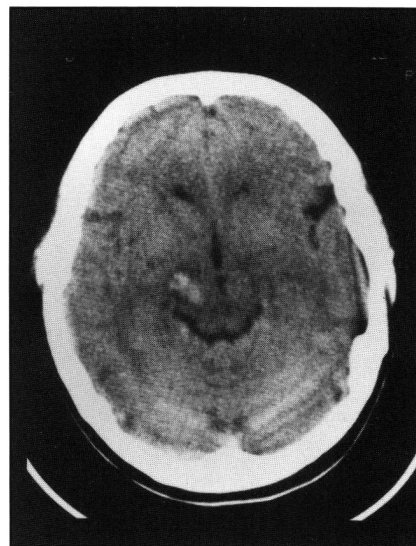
This CT scan of patient 1, without contrast, shows an area of hyperdensity in the right lateral tegmentum. Repeat CT scan 10 days later showed the hematoma to have resolved completely.
